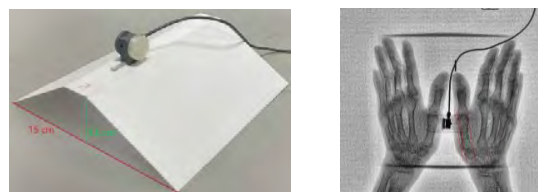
The main body of the custom stress-view evaluation system(left). The radiographic image used to determine the CMC joint radial subluxation ratio, where A indicates the amounts of the first metacarpal subluxation from the trapezium, and B represents the total width of the base of the first metacarpal bone (right)
